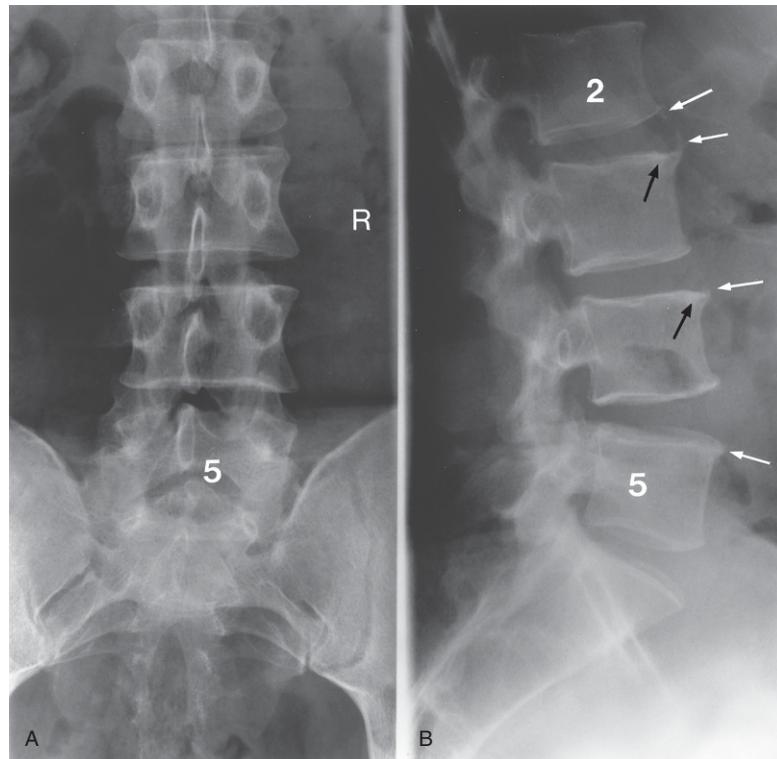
(A) Pelvis and lumbar spine erect anteroposterior plain X-ray image (cropped). Note the minimal lumbar scoliosis and the apparently normal sacroiliac joints. 5 = fifth lumbar vertebra; R = right side of patient. (B) Lumbosacral lateral plain X-ray image. Note the early thin bridging osteophytes, particularly at the anterior margins of the L2-3 intervertebral disc space (white arrows), with adjacent sclerotic changes in the intervertebral body endplates anteriorly (black arrows). 2 and 5 represent the second and fifth lumbar vertebrae, respectively.
